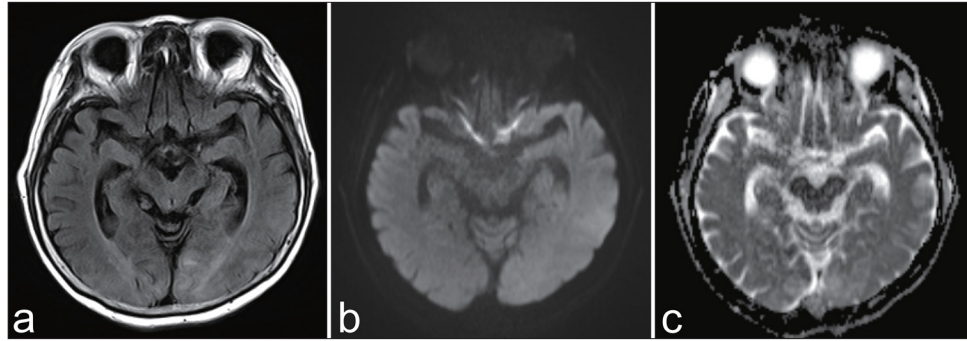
(a) Fluid-attenuated inversion recovery (FLAIR) scan 20 h post-diagnostic angiography, displaying hyperintense areas in the white matter of the parieto-occipital region. (b) Diffusion-weighted imaging reveals no parieto-occipital changes. (c) Apparent diffusion coefficient map revealing hyperintensity in the same area as seen on the FLAIR scan.
